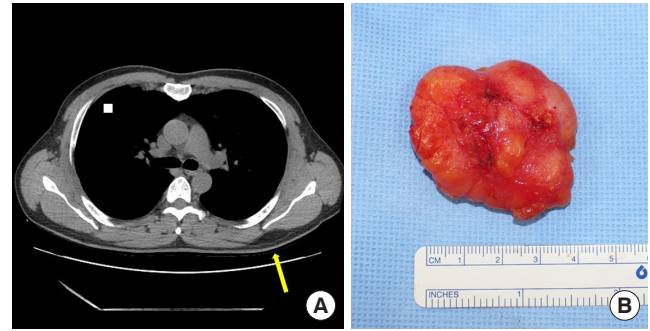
Discrepancy between the actual depth of the non-facial lipoma and the predictive depth of the preoperative diagnosis. (A) Preoperative computed tomography finding: a well-defined, non-enhancing, fat-attenuated mass measuring approximately 5.3×4.2×1.4 cm located in the deep subcutaneous layer of the left subscapular area, suggestive of a lipoma (arrow). (B) The record of the operative note: a 4.5×4×2 cm lobulated, firm mass located beneath the rhomboid muscle fascia, firmly attached to the muscle.
